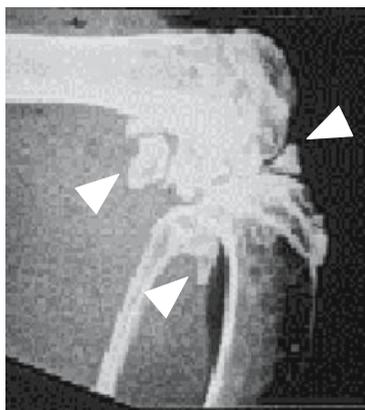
Ectopic ossification in *ttw*. Lateral radiograph of the knee joint of *ttw* shows marked ectopic ossification of soft tissues around the joint (meniscus, capsule, and ligament)
